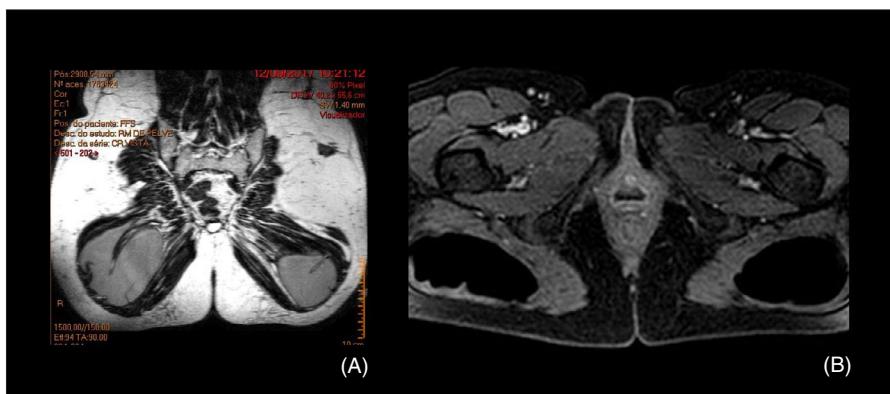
A, Coronal T1-weighted and B, axial T1-weighted MRI image with fat saturation demonstrates bilateral folds of elastomer and capsular thickness
